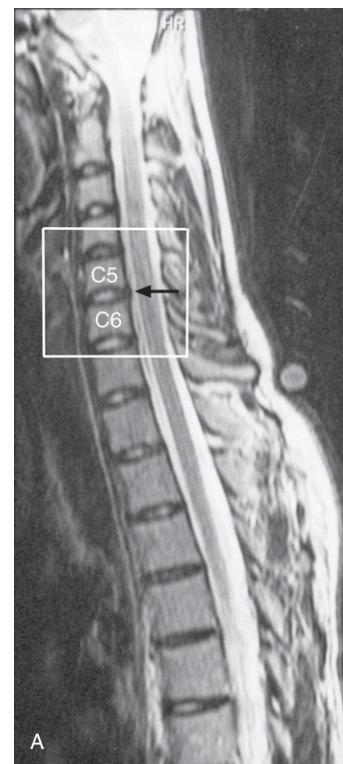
(A) Cervical spine MRI sagittal T2-weighted image. Note the central posterior disc bulge at C5–6 (black arrow). The white rectangle represents the magnified view (B) shown above.
